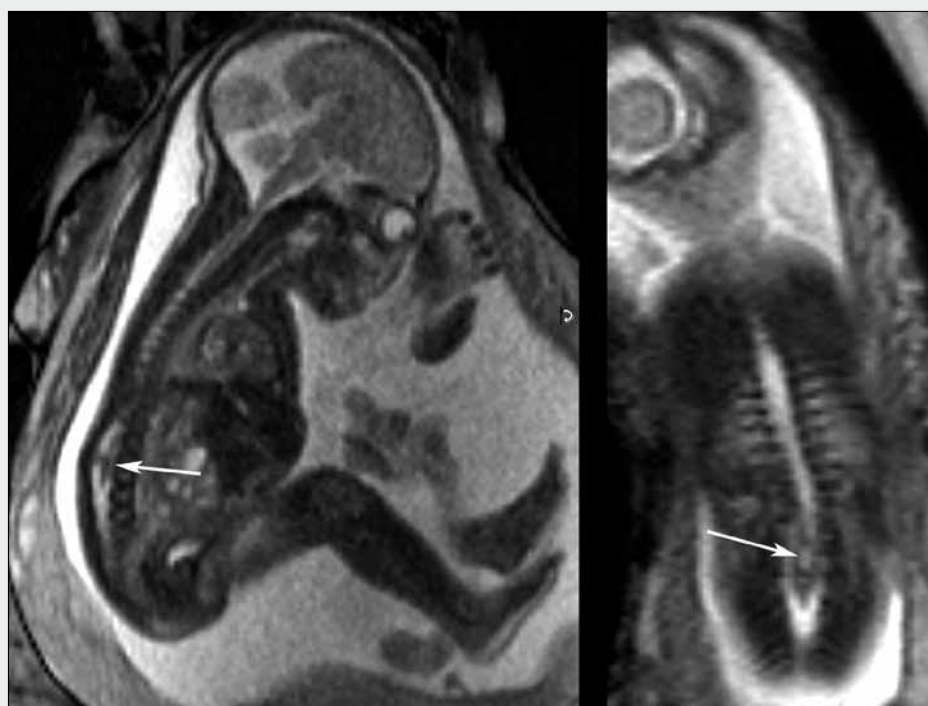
Prenatal MRI showing diastematomyelia in L3 level
